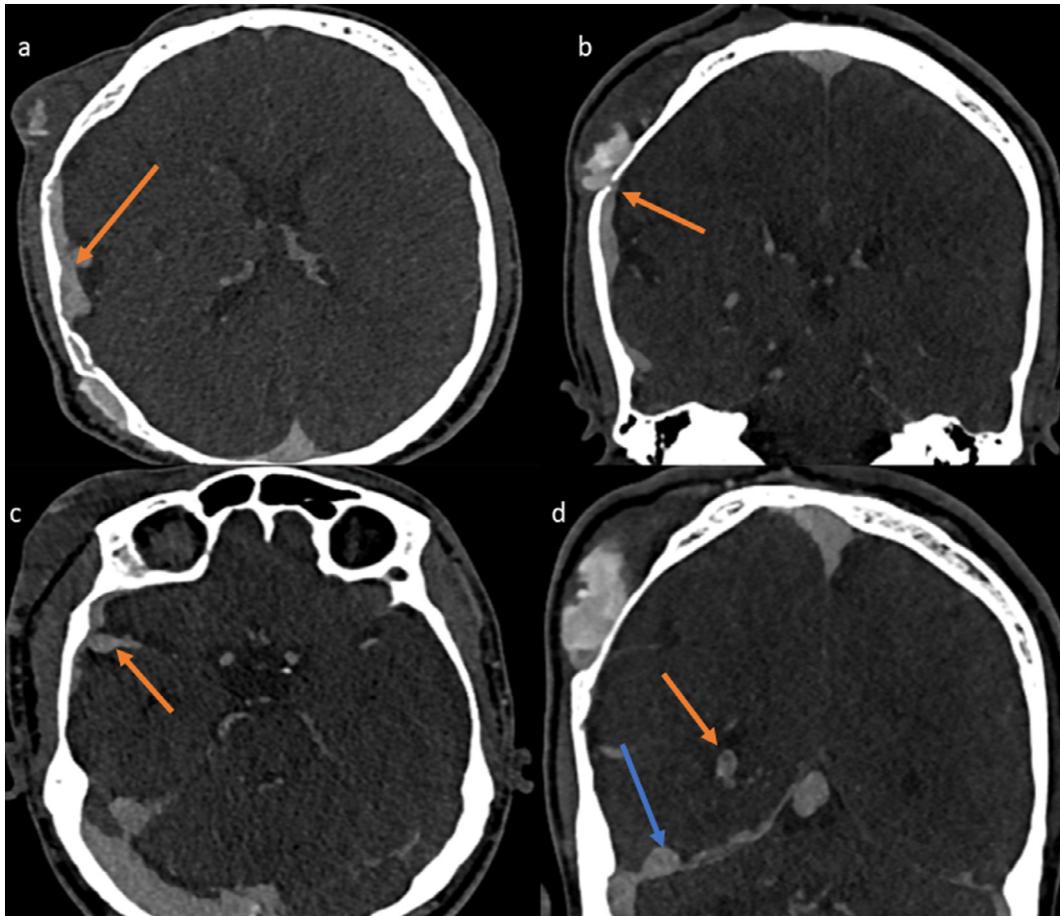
(a) Axial CT venogram shows an abnormal venous structure along the right frontoparietal convexity (arrow) which could represent a meningeal venous angioma. (b) Coronal CT venogram shows the abnormal venous structure along the right frontoparietal region communicating with the extracranial venous malformation through transdiploic venous channels (arrow). (c) Axial CT venogram shows venous ectasia (arrow) along the course of the right superficial middle cerebral vein within the right Sylvian fissure. (d) Coronal CT venogram shows prominence of right choroid plexus (orange arrow) and abnormal venous channels along the right tentorial leaflet (blue arrow).
